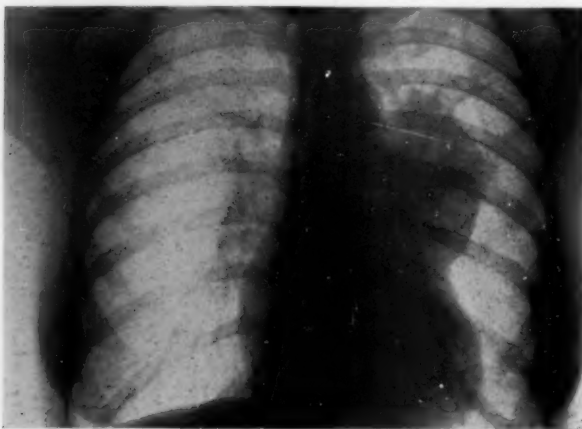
X-ray of chest taken May 11, 1925, showing the gradual increasing size of the tumor.
